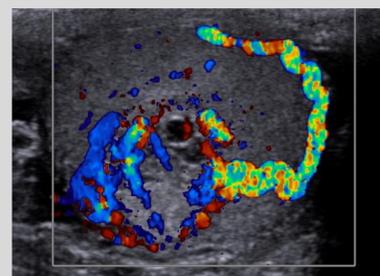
Hypervascularisation of the testicular RCC metastasis with colour Doppler.
